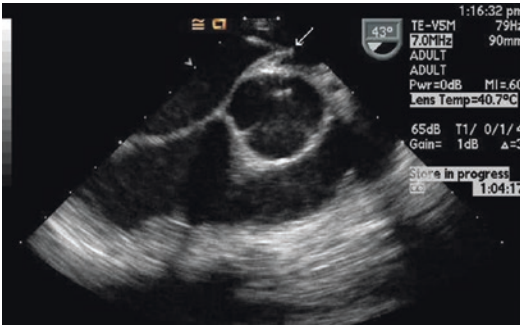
Typical transesophageal image guiding transseptal puncture. Arrow identifies tip of dilator as it “tents” the atrial septum prior to advancing the transseptal needle
